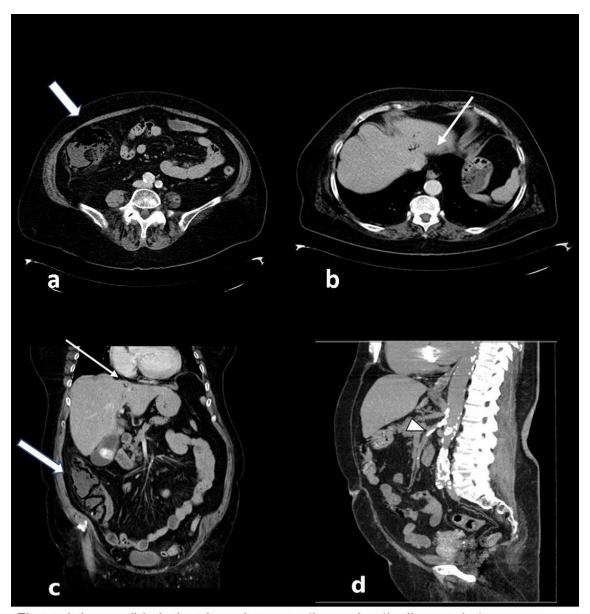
Irreversible ischemia and severe atherosclerotic disease. Late venous phase contrast enhanced axial scan (a, b) and coronal scan (c). Thin-walled ascending colon, with pneumatosis and no apreciable enhancement of the wall (thick arrow) and portal pneumatosis (thin arrow). (c) There are also gallstones and gallbladder wall thickening. (d) Sagittal non enhanced CT scan, which was done 2 years before, reveals calcification from atherosclerotic changes of aortic artery, celiac trunk and superior mesenteric artery with stenosis of the lumen. Cardiac valve prosthesis.
